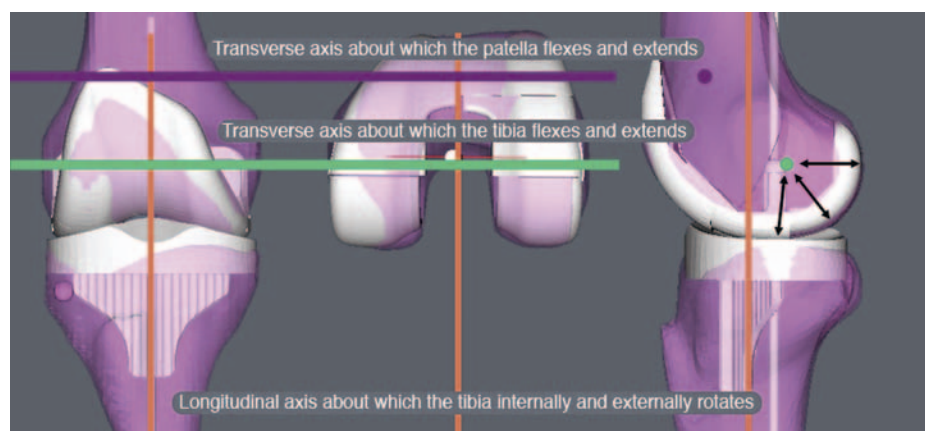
Single-radius femoral component of a right knee (*silver*) shape-matched to the femur of a normal knee model (*pink*). Shape matching the femoral component to the femur is the critical step in kinematically aligning the knee and in reestablishing the orthogonal interrelationships among the three kinematic axes. A kinematically aligned femoral component greatly simplifies the step-wise algorithm for identifying the correct options for restoring motion and balance to the knee before cementation of the components. The principle for kinematically aligning the tibial component to the femoral component is to align the anterior-posterior axis of the tibial component perpendicular to the transverse axis in the femur and femoral component. The principle for kinematically aligning the tibia to the tibial component is to accept the assumption that the internal-external rotational relationship between the femur and tibia is normal in a non-weight-bearing MRI scan and then center the tibia under the center of the tibial component.
